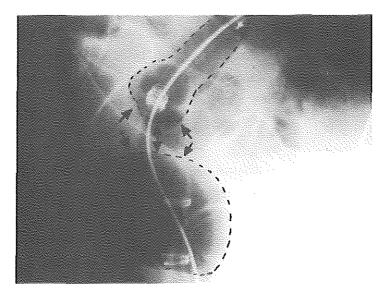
Radiographic view of correct position of inflated bag and balloon. There is no direct contact between bag and balloon.
